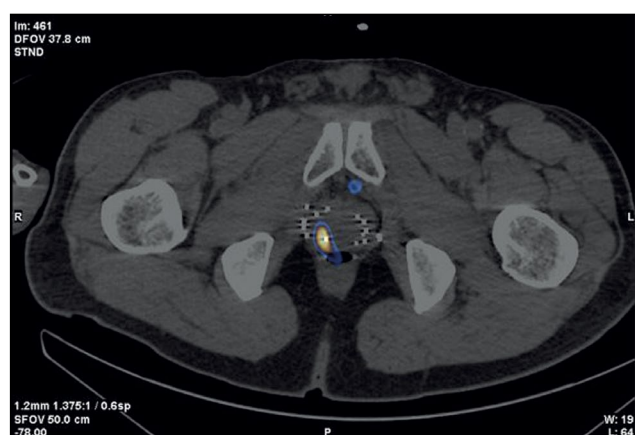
Patient K., 73 years old, SPECT /CT with  $^{99m}\text{Tc}$ -HYNIC-PSMA, (a) frontal and (b) axial sections: Sites of radiopharmaceutical accumulation in the anterior part of the transition zone in the apex of the right lobe, posterolateral part of the peripheral zone at the level of the base of the left lobe, and posterolateral part of the peripheral zones at the level of the base and middle third of the left lobe of the prostate gland; physiological accumulation of radiopharmaceuticals in the bladder.
